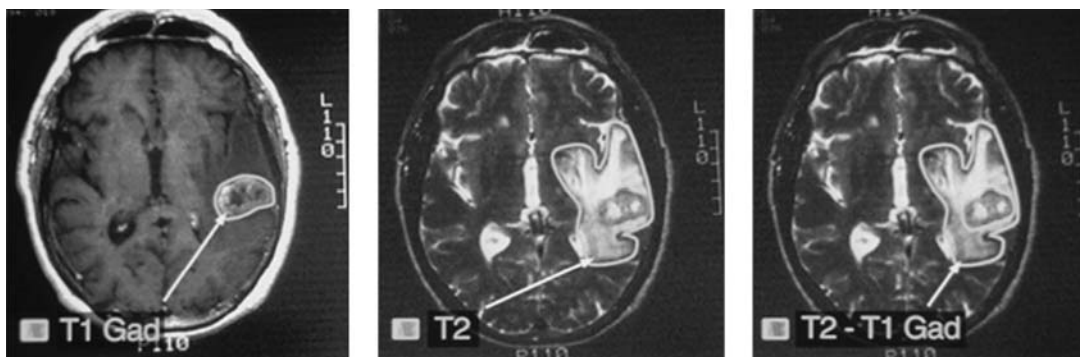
An MR image of a glioblastoma demonstrating the different components of HGGs with central necrosis, surrounding solid tumor delineated by contrast-enhancing tissue and peripheral edema indicating a zone where infiltrative tumor cells reside. Gad, gadolinium.
